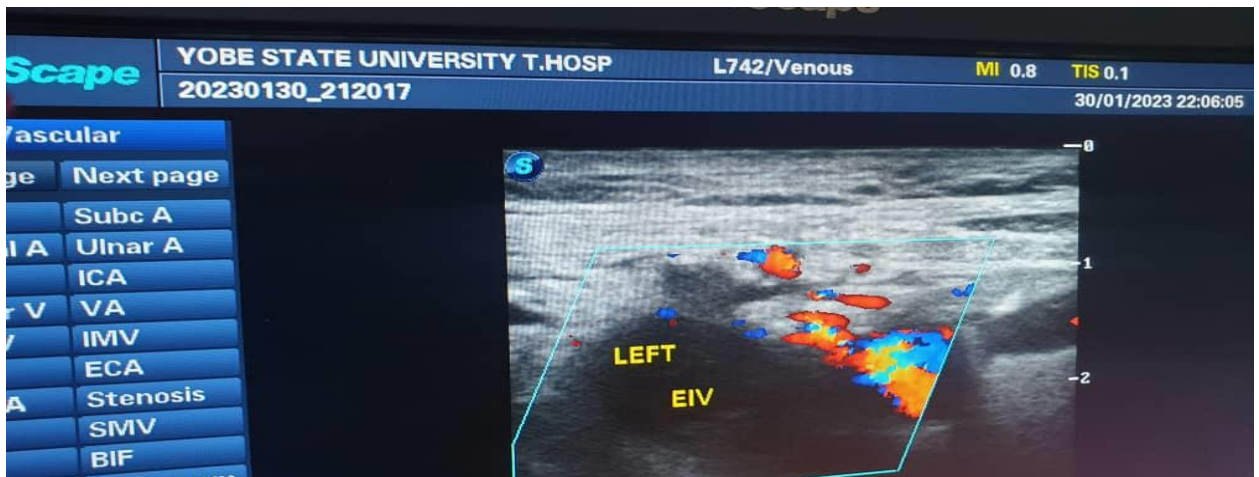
High resolution sonogram through the pelvis with colour Doppler in transverse section showing filling defect in the left external iliac vein due to thrombus.
